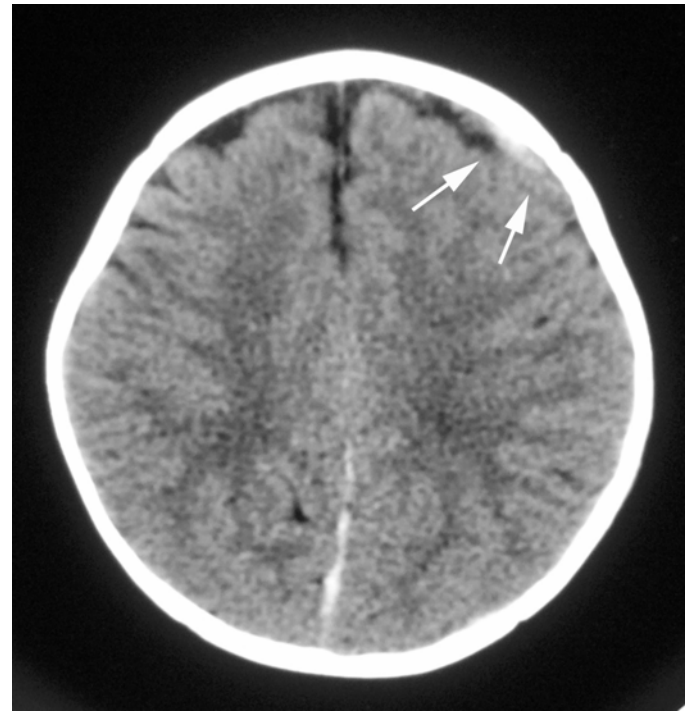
Companion case 2. Noncontrast axial head CT of the brain in the same patient shows a small amount of asymmetric high density material with a crescentic shape, located at the left frontal subdural space (arrows), consistent with an acute subdural hematoma. The presence of the acute subdural hematomas and suspicious clinical history led to a skeletal survey (not shown), which revealed multiple skeletal fractures of different ages, consistent with the diagnosis of nonaccidental trauma.
